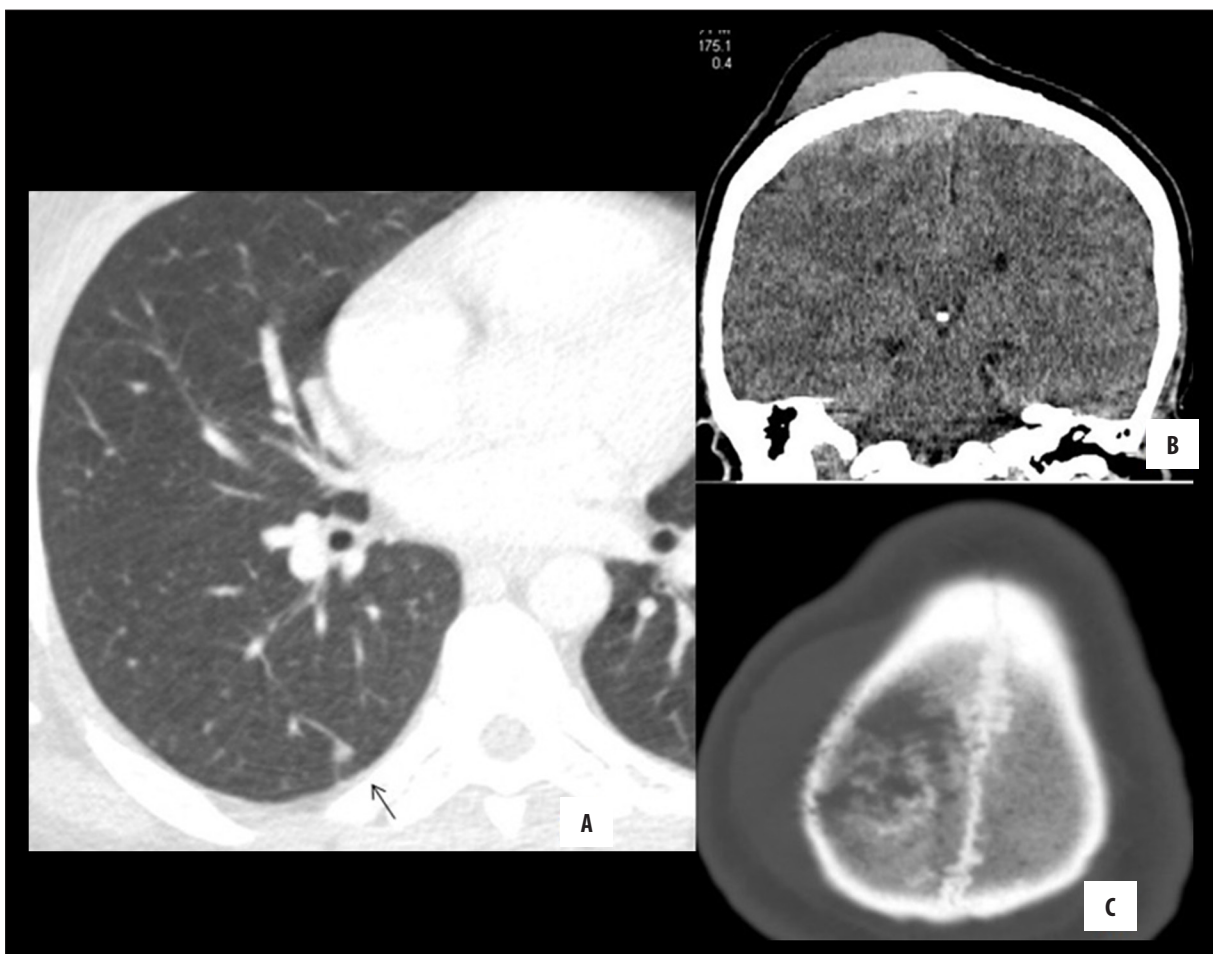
The chest CT image reveals a metastatic right pulmonary nodule in the right lower lobe (arrow in A) and soft tissue (B) and bone window (C) images of the right parietal bone metastasis are shown in cranial CT.
